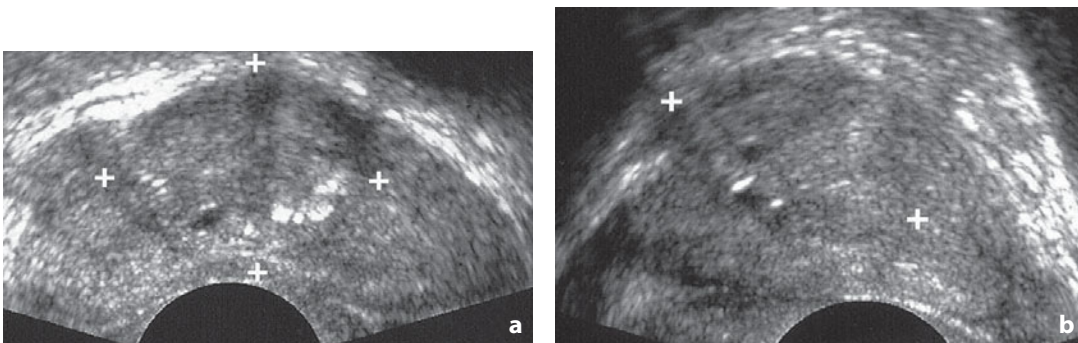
Ultrasonography. Transrectal approach, axial (a) and sagittal (b) scans. Benign prostatic hyperplasia. The crosses placed at the margins of the adenoma are used to calculate the weight
